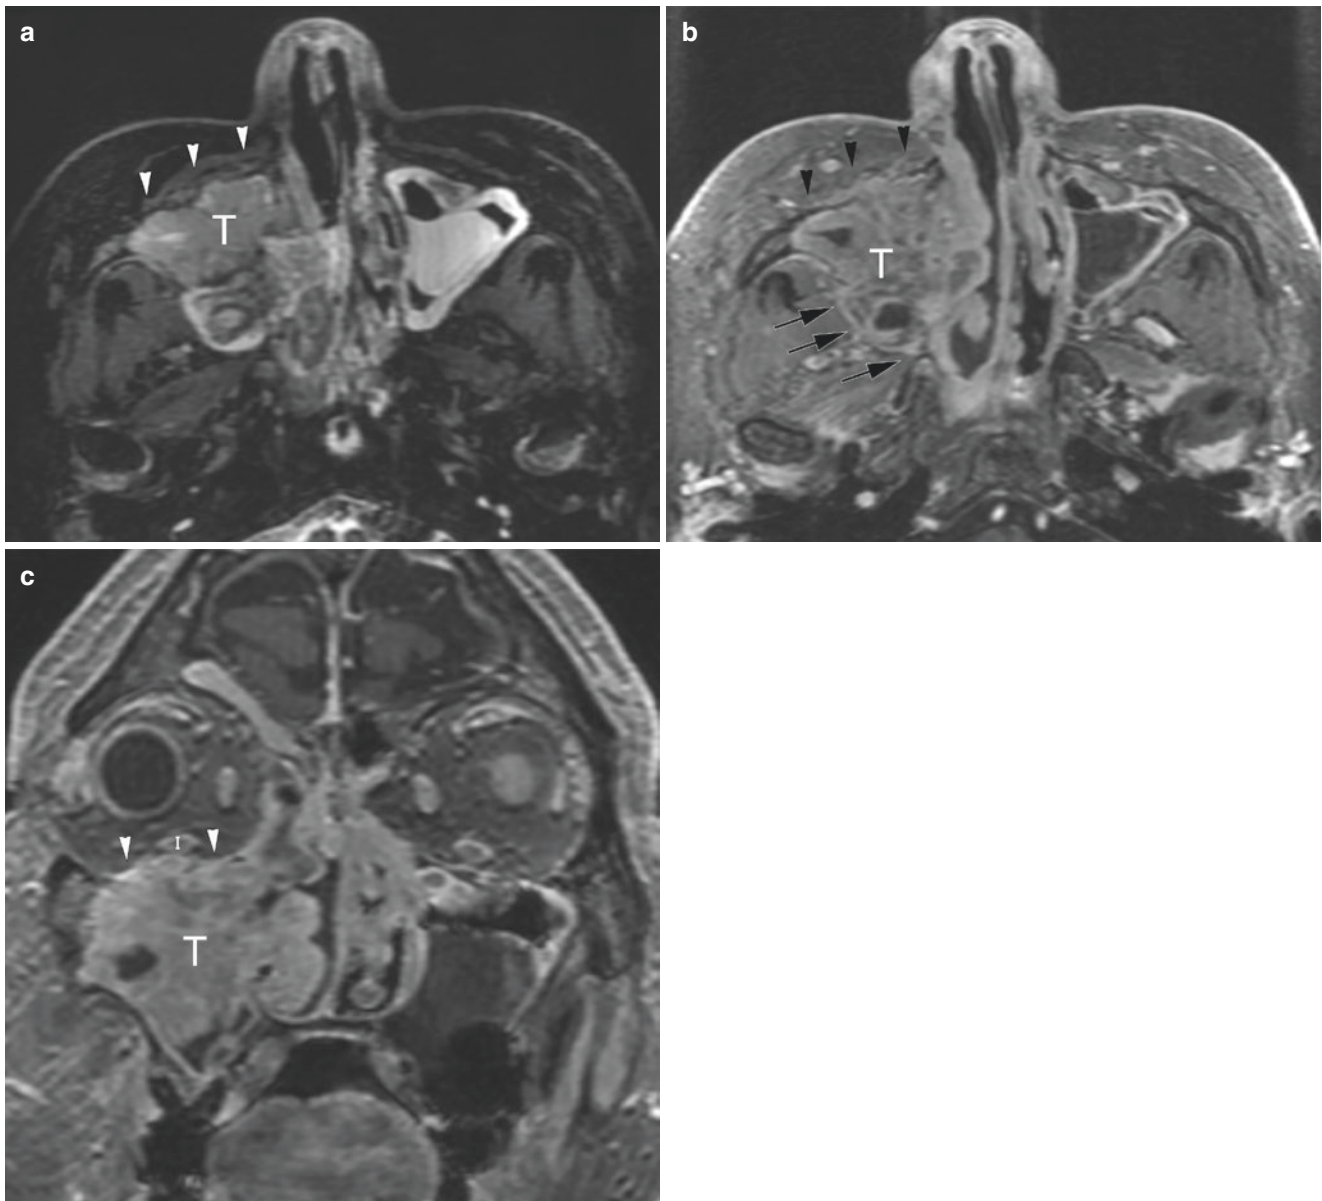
Squamous cell carcinoma of the maxillary sinus. (a) Axial T2-weighted image. (b) Axial Gd-enhanced T1-weighted image. (c) Coronal Gd-enhanced T1-weighted image. Axial T2-weighted (a) and postcontrast T1-weighted (b) images demonstrate a solid mass (T) that nearly fills the right maxillary sinus, with slight invasion to anterior subcutaneous fat (arrowheads). The axial contrast-enhanced
